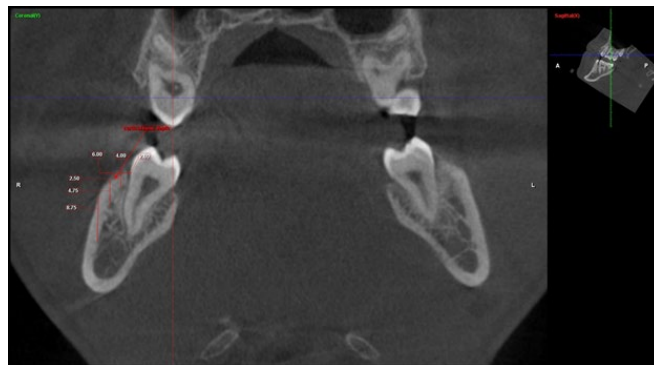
showing Sagittal Plane in Red Line Passing through Centre of Alveolus Parallel to the Distal Roots of the Lower First Molar (M6) and Distal Root of the Lower Second Molar (D7) on Coronal View of Cone Beam Computed Tomography.
